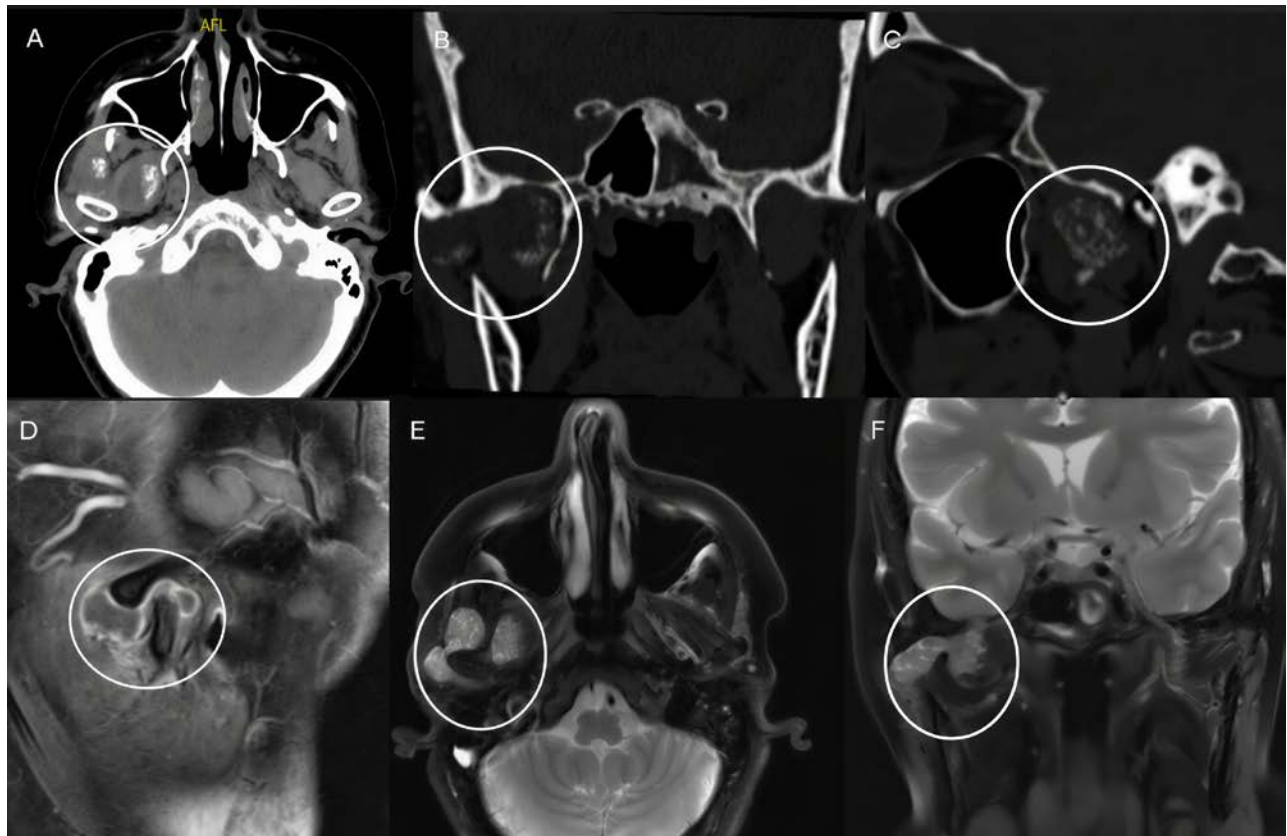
Axial CT (soft tissue window) shows multiple soft tissue calcifications (A, red circle) at the right TMJ. Coronal and sagittal CT (bone window) show multiple calcified loose bodies of uniform size and widening of the right TMJ (B-C, red circles). Sagittal post contrast T1-WI of the right TMJ show peripheral wall enhancement representing slightly thickened synovium (D, red circle). Axial and coronal T2-WI with fat suppression show multiple loose bodies in the joint, most of which are of low signal intensity (E-F, red circles).
